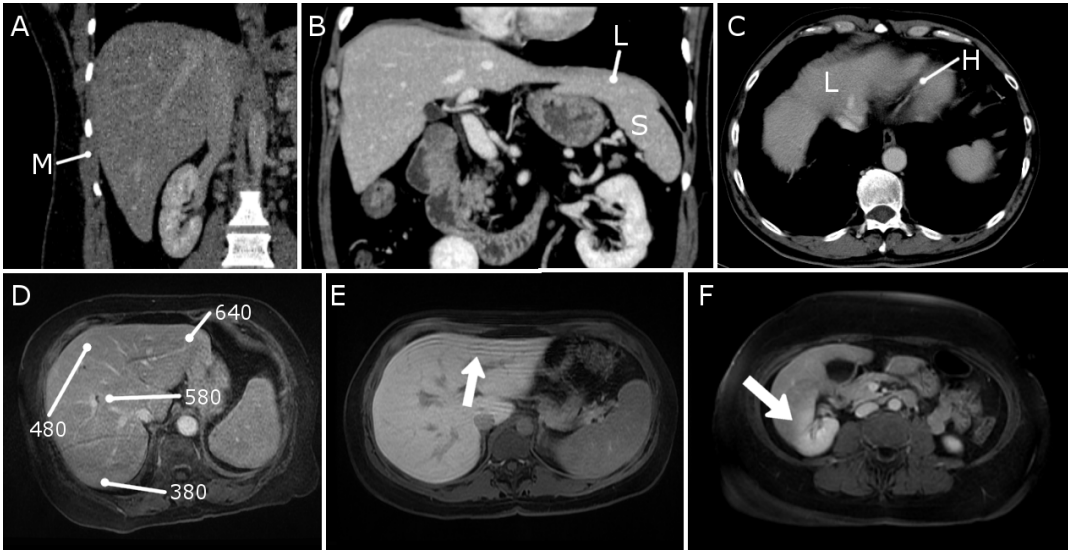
Common liver segmentation pitfalls on CT and MRI.
